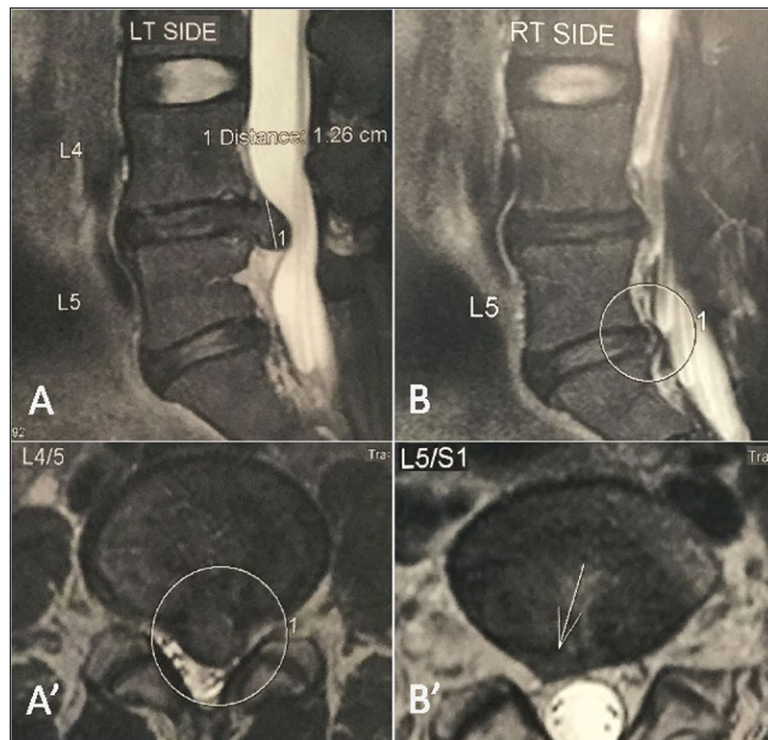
Lumbar magnetic resonance imaging. A magnetic resonance imaging showed (A, A') a pronounced disc extrusion towards the posterior central and left subarticular zones at L4/5 level, and (B, B') another disc protrusion in right L5/S1 subarticular zone. Impingement onto the left L5 traversing nerve root was noted.
